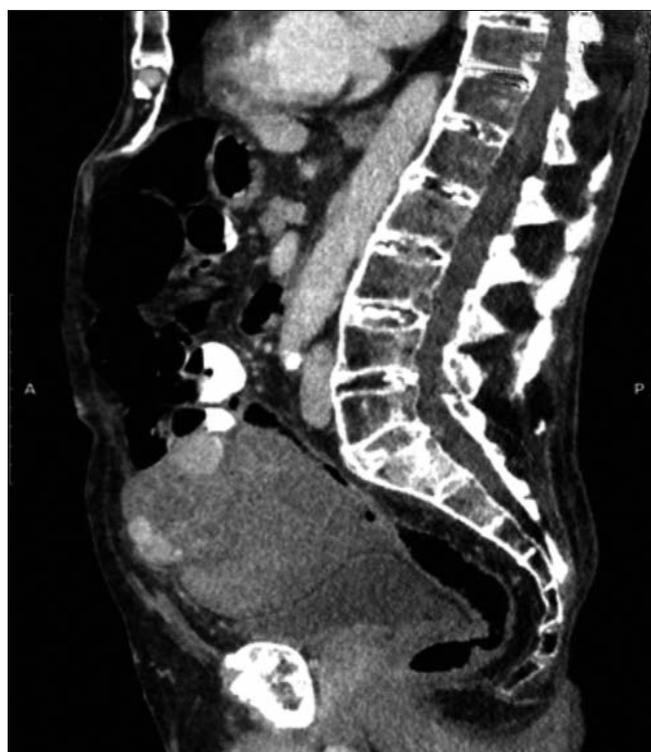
Abdominal CT - Sagittal view
